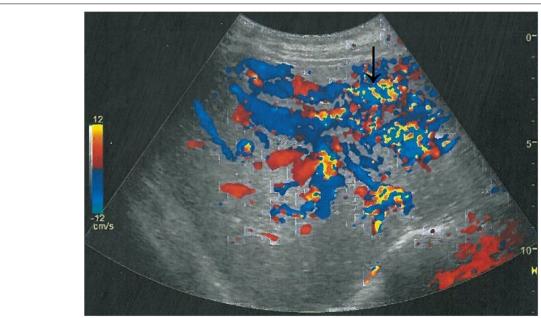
Abdominal Doppler Ultrasound image of portal vein shunts
